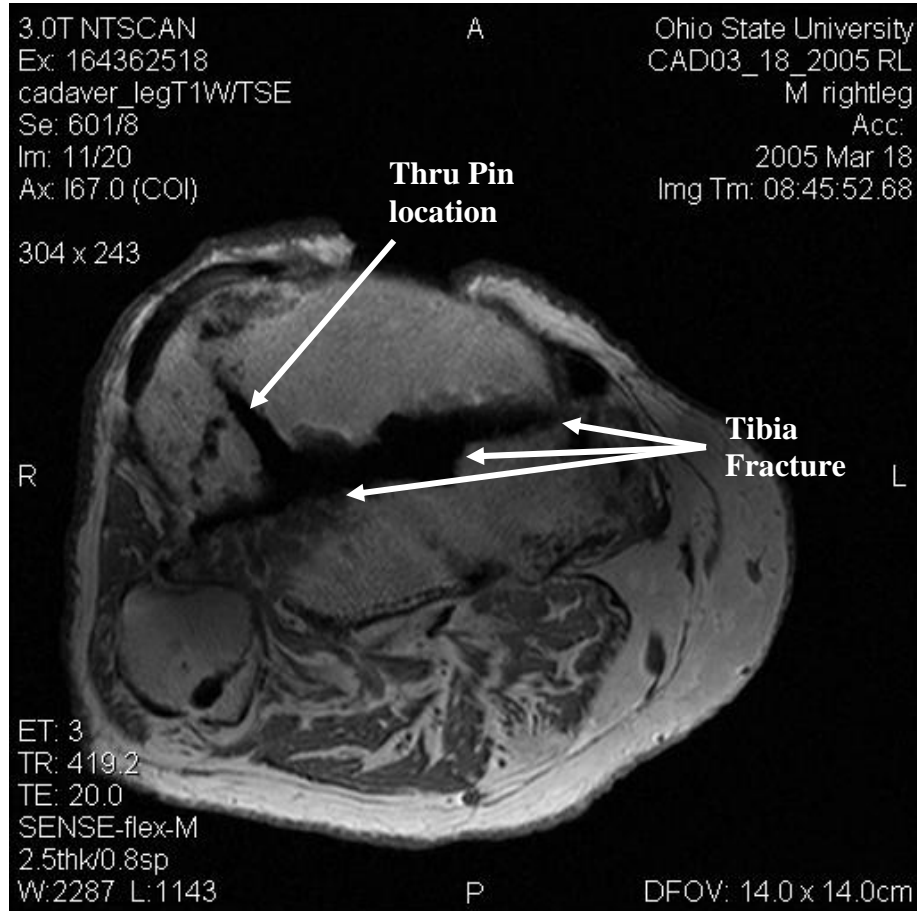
Post-Test MRI of Subject 0502HTIR
